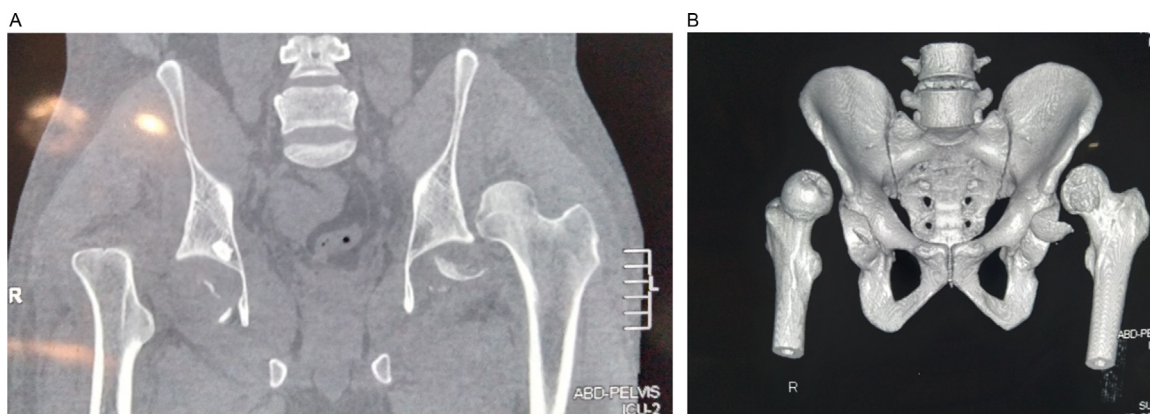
(a) The Coronal image (CT) shows bilateral fracture-dislocation of the hip. (b) shows the 3D reconstruction image of the pelvis and both hips showing asymmetrical fracture-dislocation of hips.
